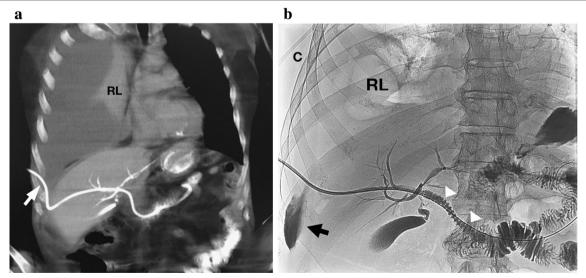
a Coronal CT MPR reconstruction of the chest and upper abdomen. There is complete obliteration of the right pleural space by the bilous effusion, complete right lung collapse (RL) with left mediastinal shift. The drainage catheter (white arrow) clearly courses through the right costophrenic sulcus. b Image of the right upper quadrant immediately after stent deployment (white arrowheads) and prior to tract embolization. Black arrow points at the opacified right pleural sulcus. The right lung (RL) has partially re-expanded. C: pleural drainage catheter
